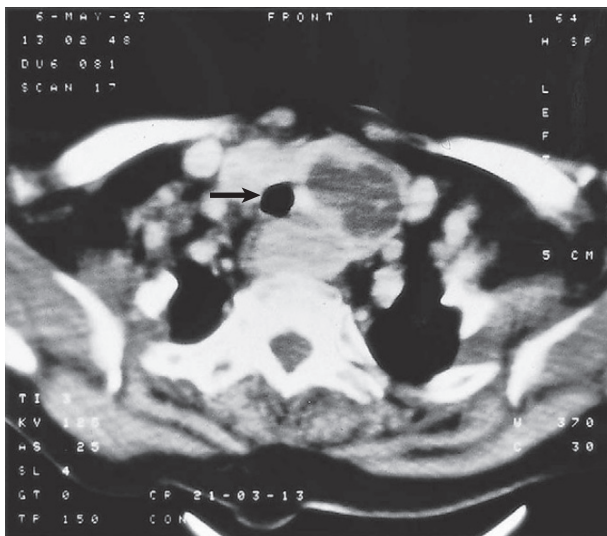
A CT scan of the neck showing a goitre (large mass in the left lobe of the thyroid gland). The trachea (arrow) is slightly deviated to the right.
